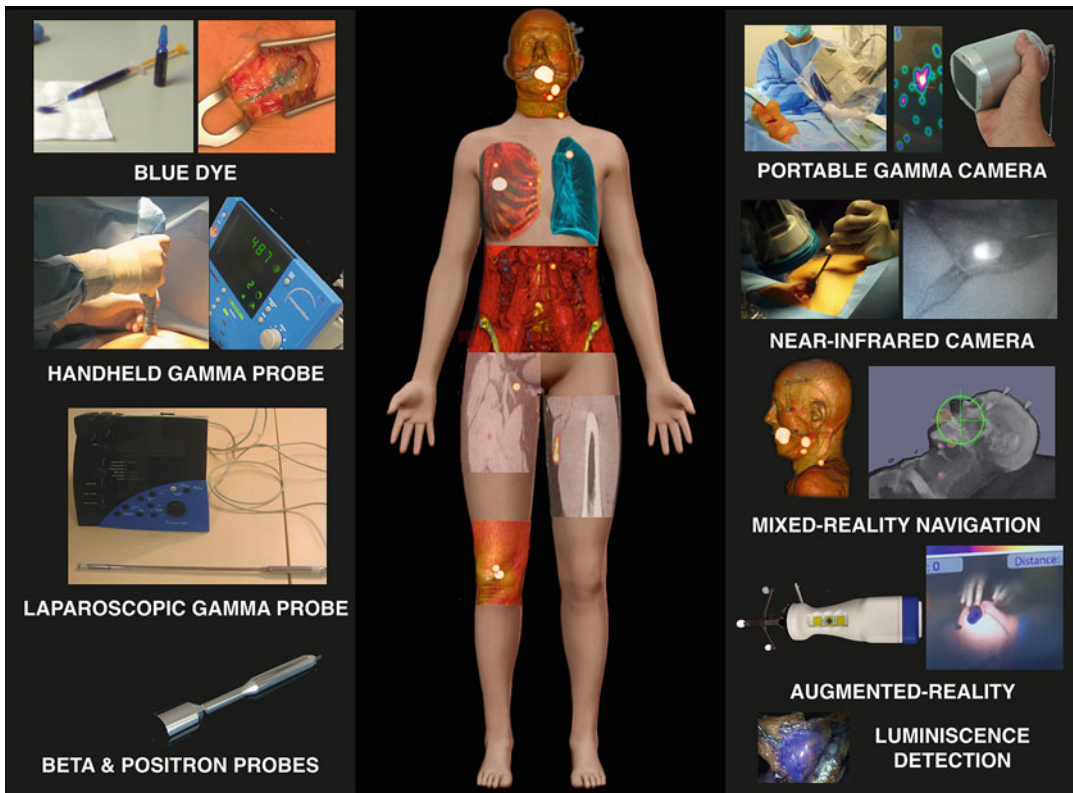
Synergy of SPECT/CT and PET/CT with portable intraoperative technologies. Both sentinel lymph nodes (head/neck, axillary/intercostal, para-aortic, inguinal, popliteal) and [^{18}F]FDG avid metastases (*upper left lung,*
